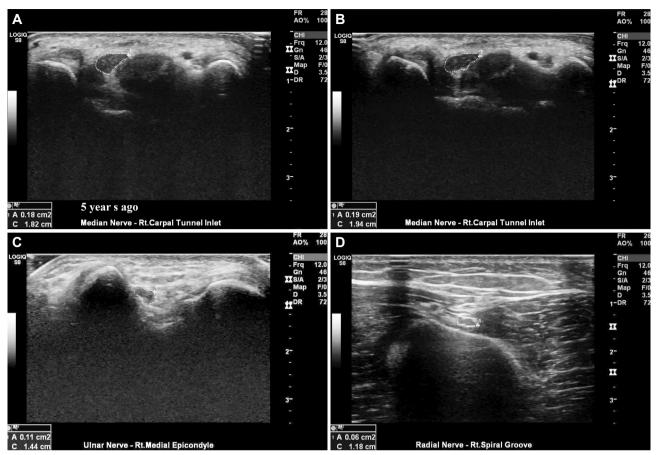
Ultrasonography findings of hereditary neuropathy with liability to pressure palsies with a novel point mutation. Ultrasonography revealed swelling of peripheral nerves at common entrapment sites: -the median nerve at the wrist (A and B) and the ulnar nerve at the elbow (C). The radial nerve did not show any nerve enlargement at the compression site (D). These findings did not differ from those in nerve ultrasonography performed 5 years previously (A and B).
